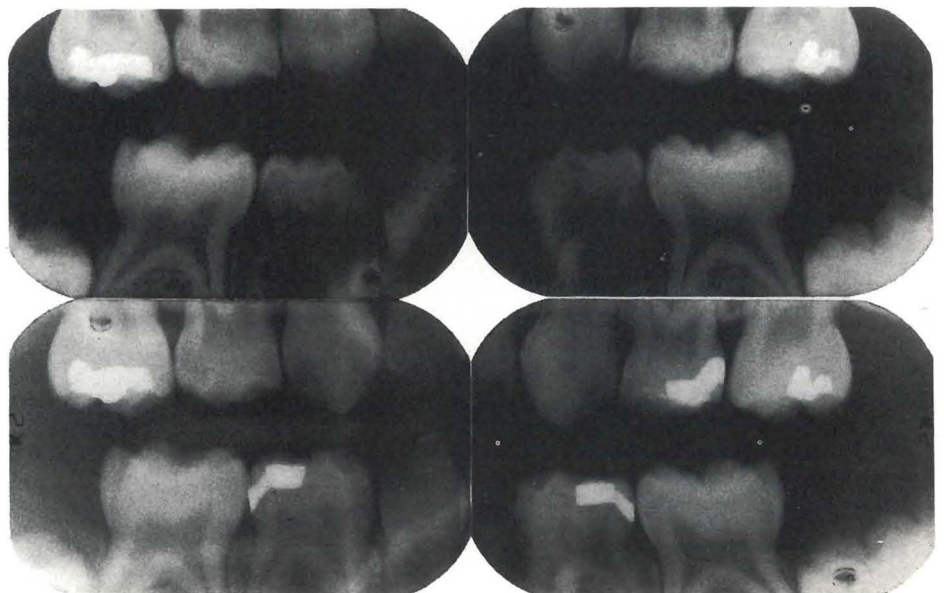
Preoperative radiographs (above) and six months postoperative radiographs (below) are shown. Both left primary first molars also were restored with Ketac-Silver tunnel restorations.
